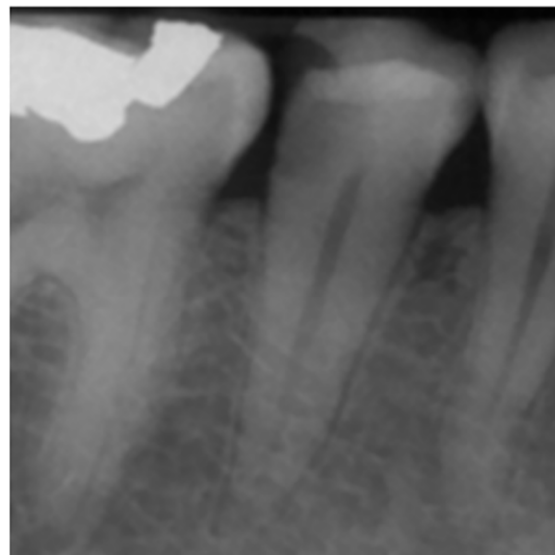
Determining a diagnosis with a radiograph only can lead the clinician to treat tooth No. 29 because of the distal decay. However, if the proper diagnostic tests are performed on tooth No. 29, it should reveal the pulp tested necrotic and it is tooth No. 30 that has a symptomatic irreversible pulpitis and was the patient's chief complaint.
